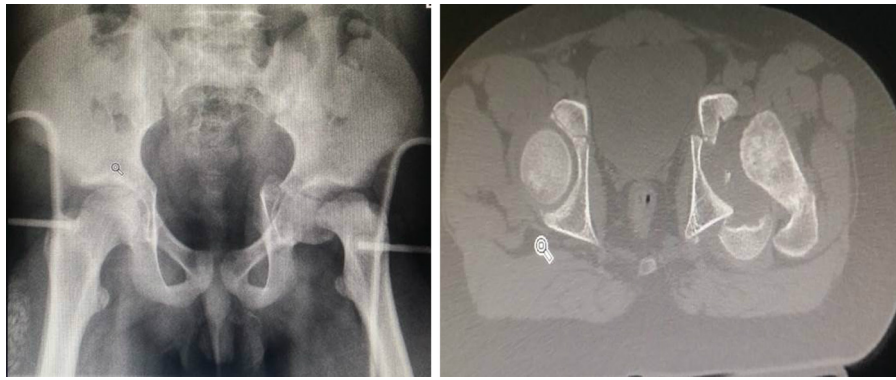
X-ray and C-scan showing complete transphyseal separation and dislocation of the femoral head associated with anterior column fracture of left acetabulum.
